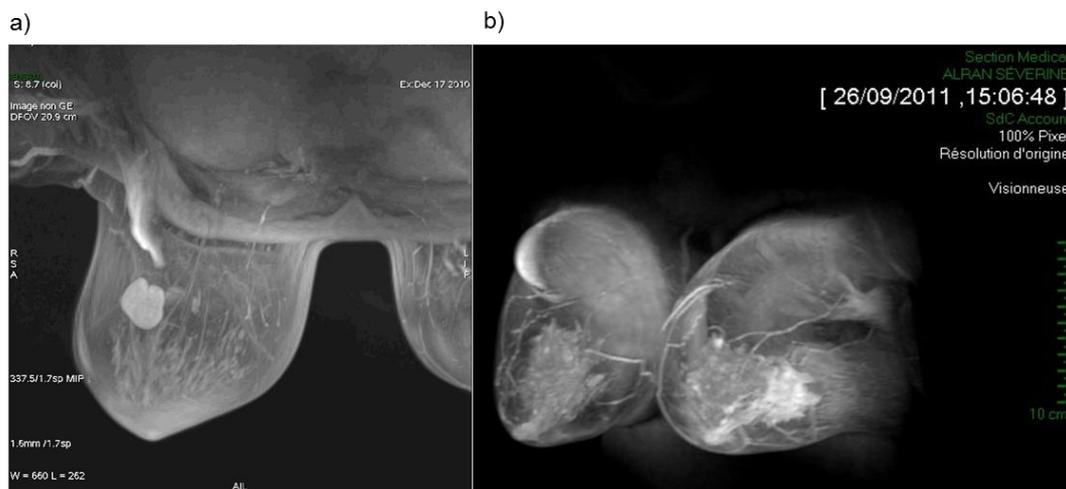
(a) MRI image of the benign lesion (*fibroadenoma*) present in Patient 02. The tumour volume calculated by MRI was 3.90cm^3 ; (b) Carcinoma present in Patient 15. The tumour volume calculated by MRI was 6.34cm^3 .
